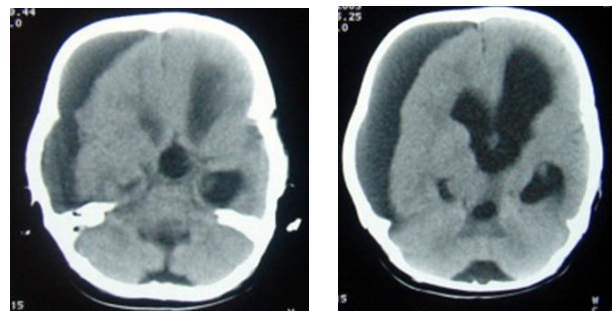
Post-operative CT showing complete removal of Teratoma
